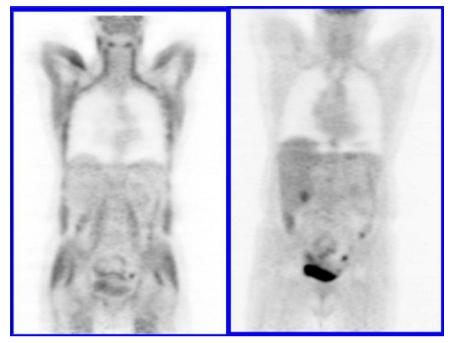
The same patient shown in Fig. 3.3, with two different blood glucose levels at the time of radiotracer administration. Left: The patient with increased blood glucose levels. Note the marked FDG uptake in the muscles and reduced uptake in the liver and brain. Right: After fasting, there is no more FDG uptake in the muscles and increased uptake in the liver.
